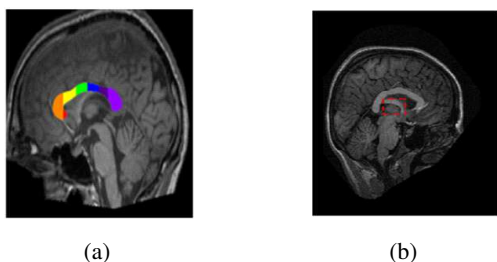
Examples of sagittal brain MRI slices: (a) CC area is composed of rostrum (in red), genu (in orange), anterior body (in yellow), mid-body (in green), posterior body (in blue), isthmus (in purple) and splenium (in light purple). (b) An example where the fornix (framed in red) appears in the neighborhood of the CC while being of similar appearance.
